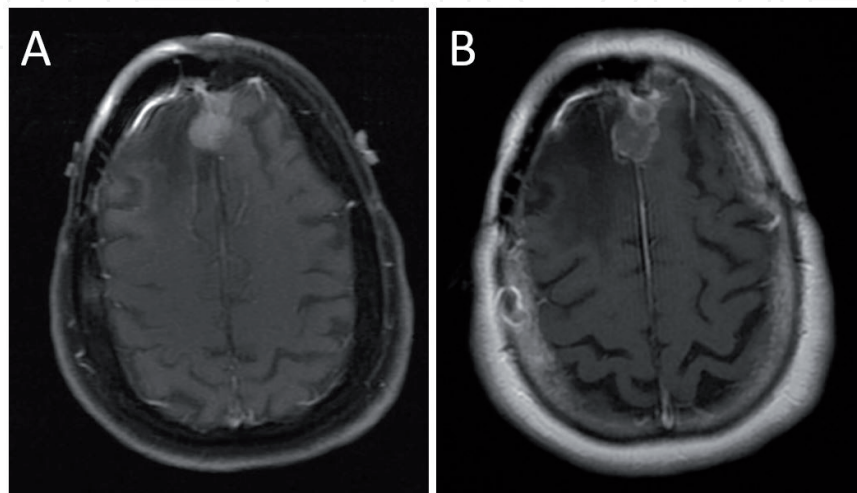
(A) Pre-operative T₁-weighted MRI with contrast showing recurrence of right parafalcine meningioma. (B) Post-operative T₁-weighted MRI with contrast showing near-total lesional ablation.
